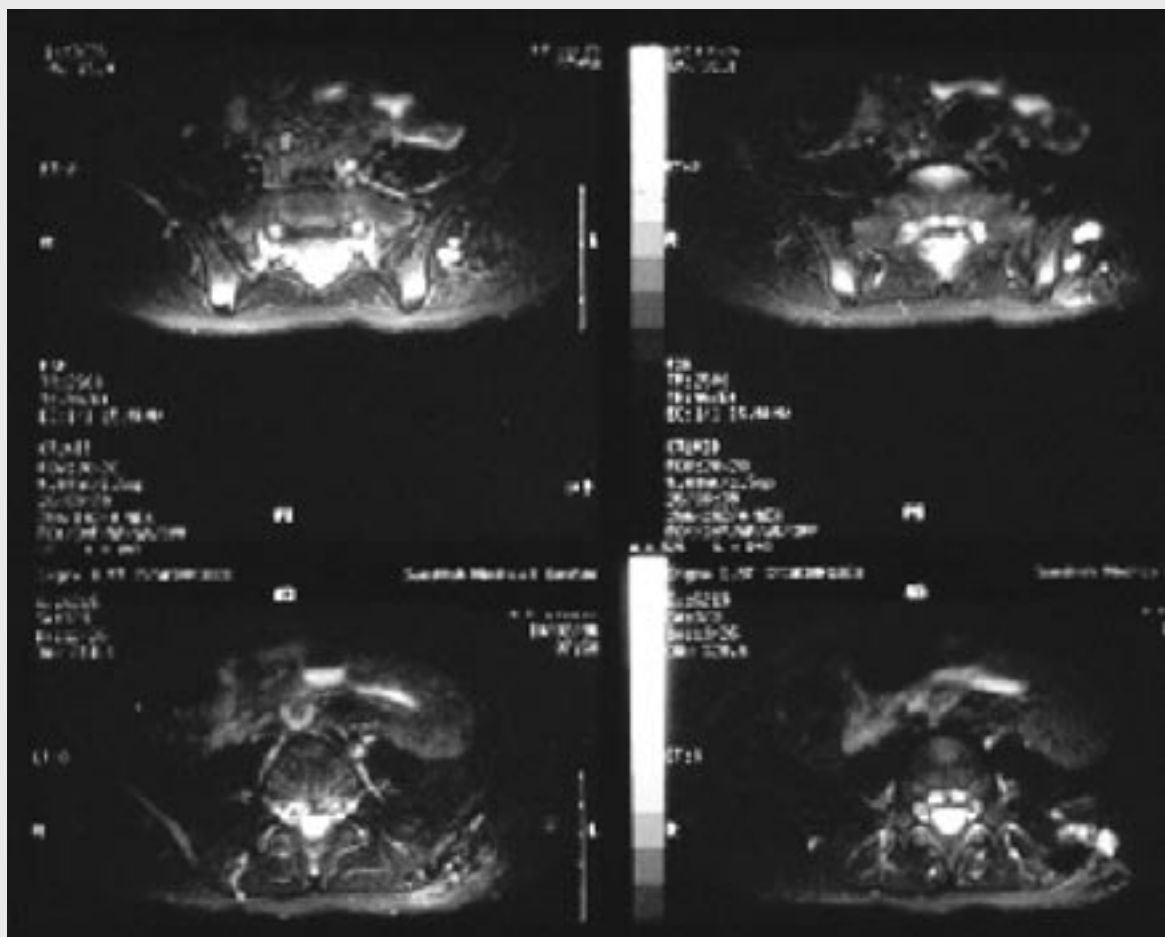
A – 5 year old female with painful growing mass in the left lower back and buttock area. Coronal T-2 fat suppressed image of lower back. Note bright signal of vein malformation in the left paraspinous area extending to the left buttock region; B – direct puncture contrast injection into the lesion with the patient in the prone position. Note the similarity of the contrast image compared to the MR image in 4A; C – axial T-2 fat suppressed image of the lower back prior to percutaneous ethanol treatment. Note the bright signal in the images of the lesion; D – axial T-2 fat suppressed images of the lower back six months after percutaneous ethanol therapy. Note remarkable absence of the vein malformation due to ethanol treatment. The patient no longer has any pain syndrome. The patient will be followed over the years with MR imaging.
